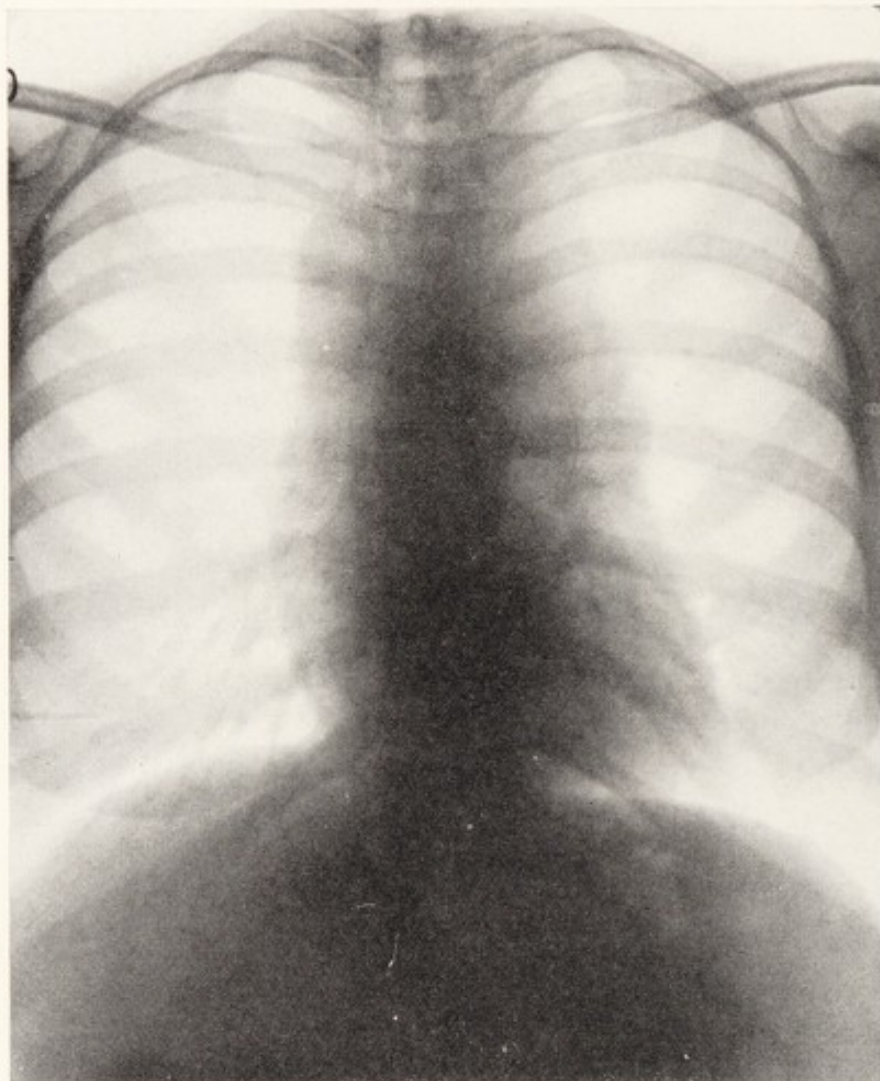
Roentgenogram of the chest shown in Fig. 88 made twelve weeks after x-ray therapy was started shows a marked reduction in the size of the mediastinal mass. This therapeutic test justified the diagnosis of Hodgkin's disease which was confirmed by biopsy.
